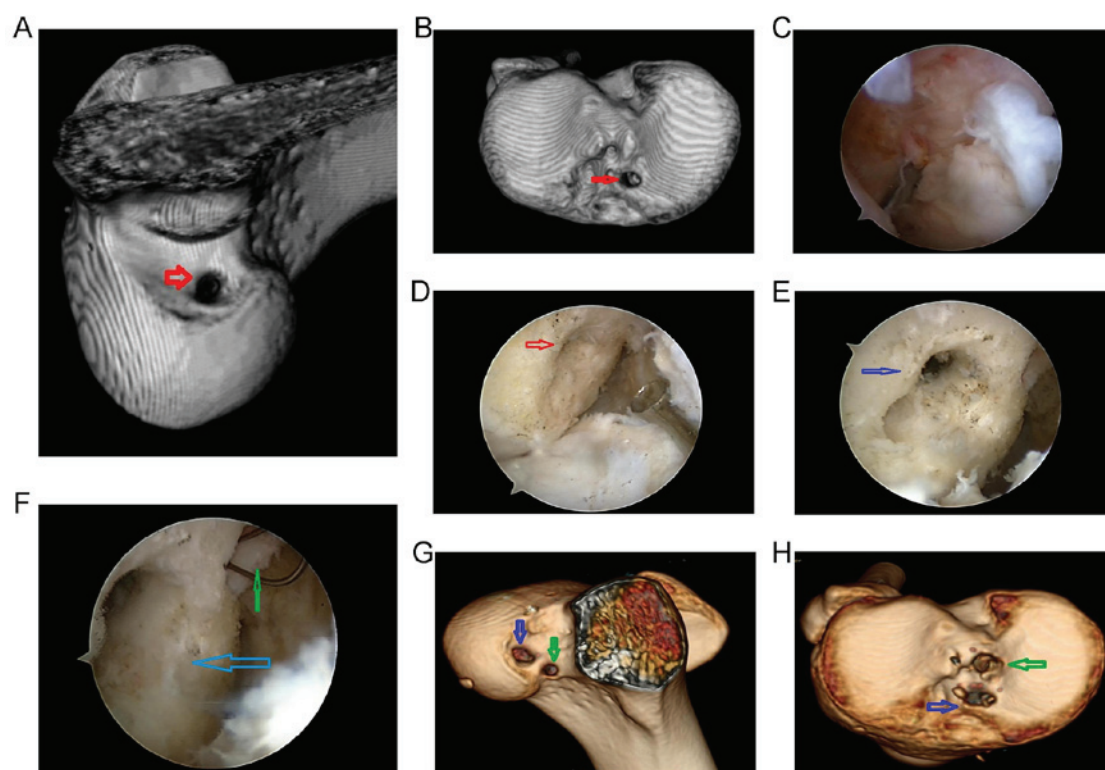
Revision surgery to rescue a failed single-bundle ACL reconstruction. (A-C) The original bone tunnel was too anterior with a narrow diameter. (D) The repaired ACL ligaments were missing during revision operation. (E) The original bone tunnel was expanded into an oval and used for the posterolateral bundle. (F) A new bone tunnel for the anteromedial bundle was constructed (green arrow). (G and H) Post-operative 3-dimensional computed tomography scan displaying the bone tunnels. Blue arrows indicate that the original femoral tunnel was used for the posterolateral bundle and the tibial tunnel for the anteromedial bundle, and green arrows indicate that the added femoral tunnel was used for the anteromedial bundle and the added tibial tunnel for the posterolateral bundle. The red arrows represent the original bone tunnel. ACL, anterior cruciate ligament.
